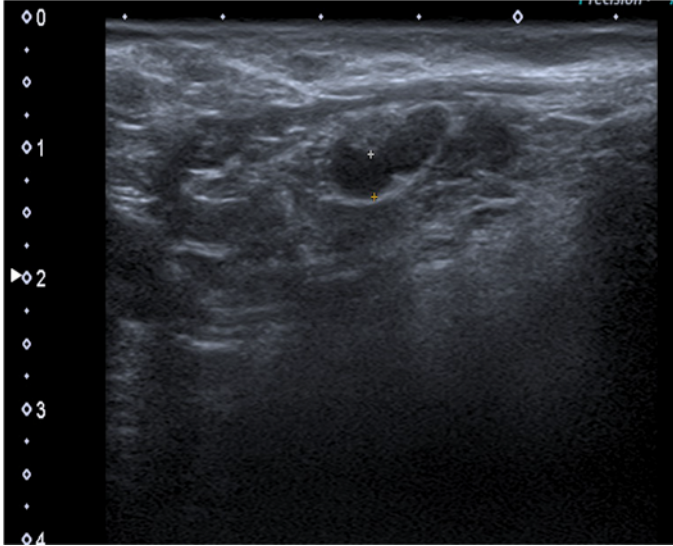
The ultrasound imagen showed an oval, well-defined hypoechoic nodule sin dermis.
